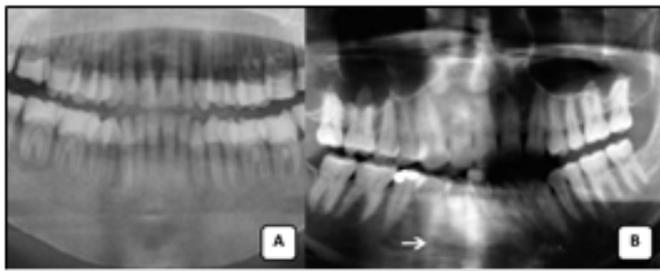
Panoramic radiograph showing (a) narrowed anterior teeth in too far forward position. adopted from: (Iannucci, 2017), (b) twisted patient's head. adopted from (Anil, 2016).
